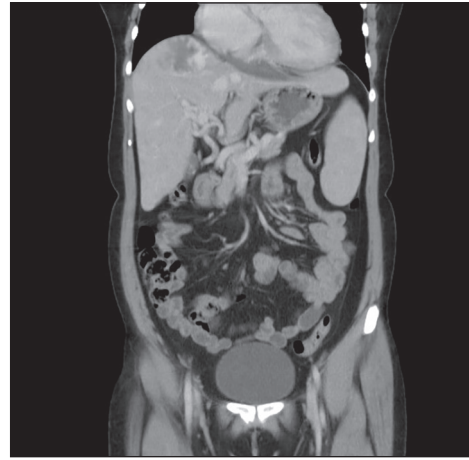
CT image showing hepatic telangiectasia
